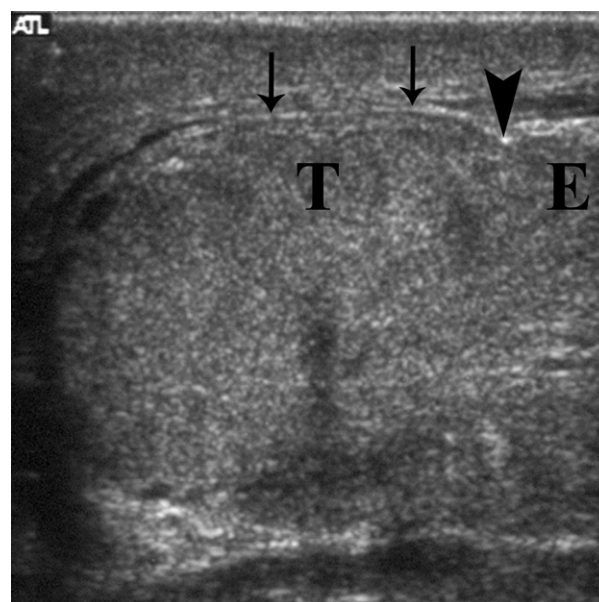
Ultrasound scan showing ruptured testis, with interruption of normal echo-rich line of tunica albuginea (arrows) at arrowhead. Extruded seminiferous tubules (E) have herniated through tunica defect. Testis (T) was markedly heterogeneous and was confirmed intraoperatively and successfully repaired.
